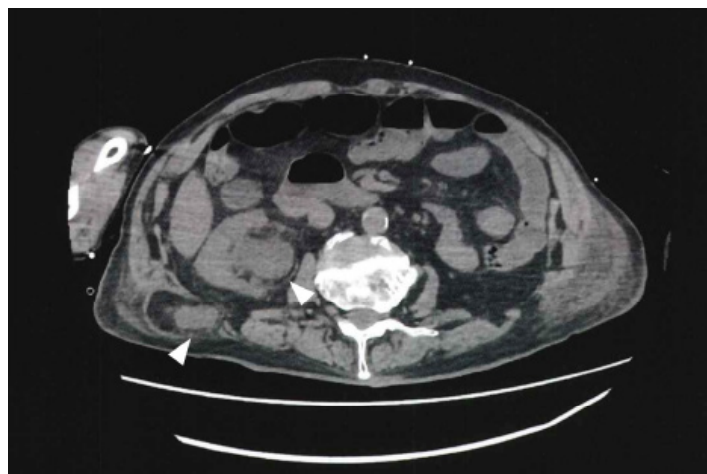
Computed tomography (axial view) showing the dilated renal pelvis and herniated ureter from the Petit triangle.
